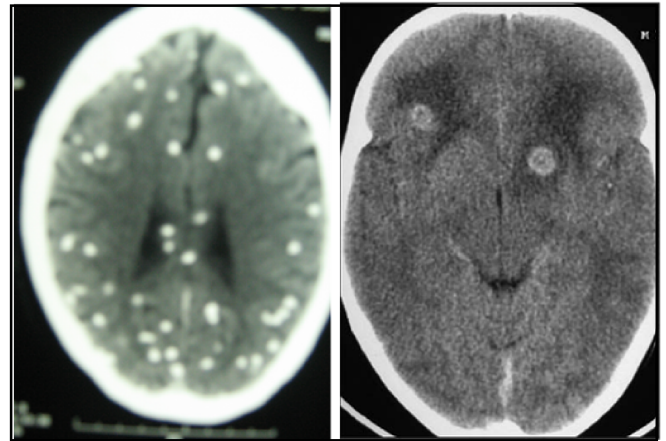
& 2 CT Scan Showing Multiple Calcified NCC lesions & NCCT Showing Tuberculomas
